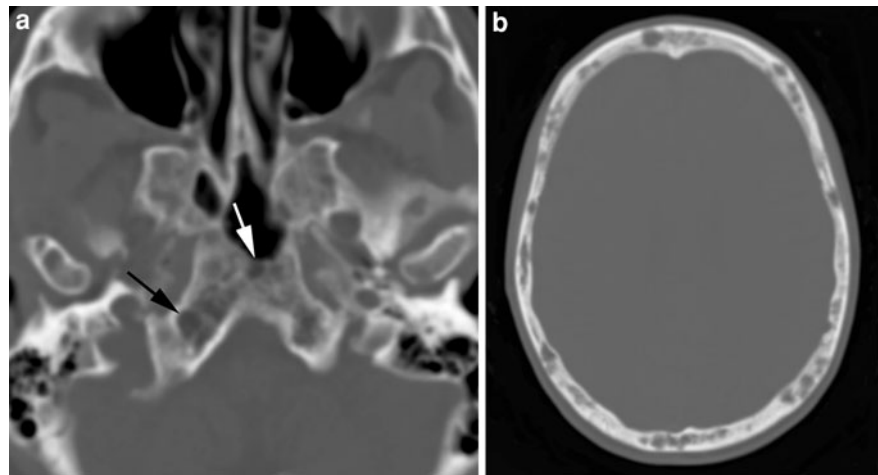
Axial CT displayed in bone window demonstrates marked expansion of the greater sphenoid wings (*arrows*) that is also more cystic in appearance within the body of the sphenoid bone on the right (*arrowhead*). Thalassemia is the underlying cause of bony expansion in this patient
